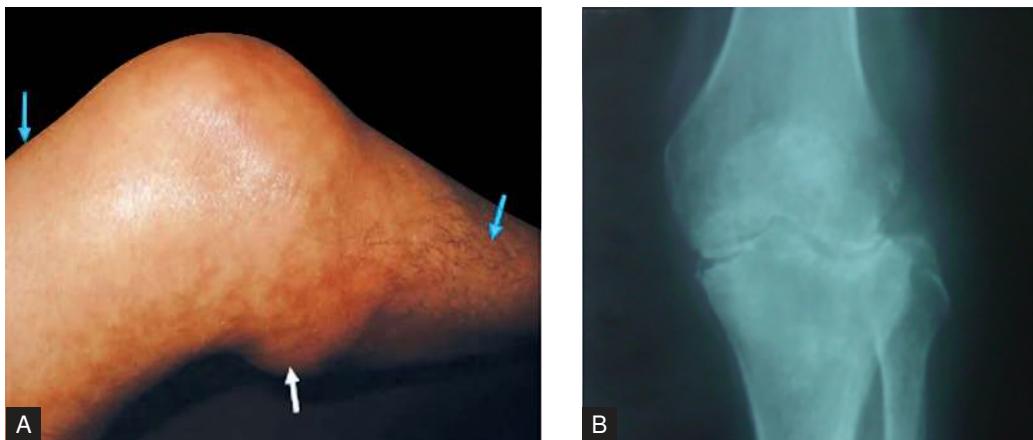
6ii.1A and B: (A) Tuberculosis of the right knee joint (proven by synovial biopsy). Note the marked wasting of the proximal and the distal muscles of the affected knee (light blue arrows); a 'cold abscess' on the posterior aspect (white arrow) is also visible; (B) The radiograph of a tuberculous joint infection showing the right knee with the following notable abnormalities: Narrowing of joint space osteopenia (bone thinning), bone destruction (irregularities or erosion in the bony structure of the knee), periarthritis osteoporosis, soft tissue swelling, formation of subluxation/dislocation: Cystic lesions/lytic areas; features typical for a chronic granulomatous inflammation caused by *Mycobacterium tuberculosis*, leading to progressive joint destruction and disability if untreated. (Courtesy: Dr Jitendra Maheshwari, Joint Replacement Surgeon, SRBRI, New Delhi)
